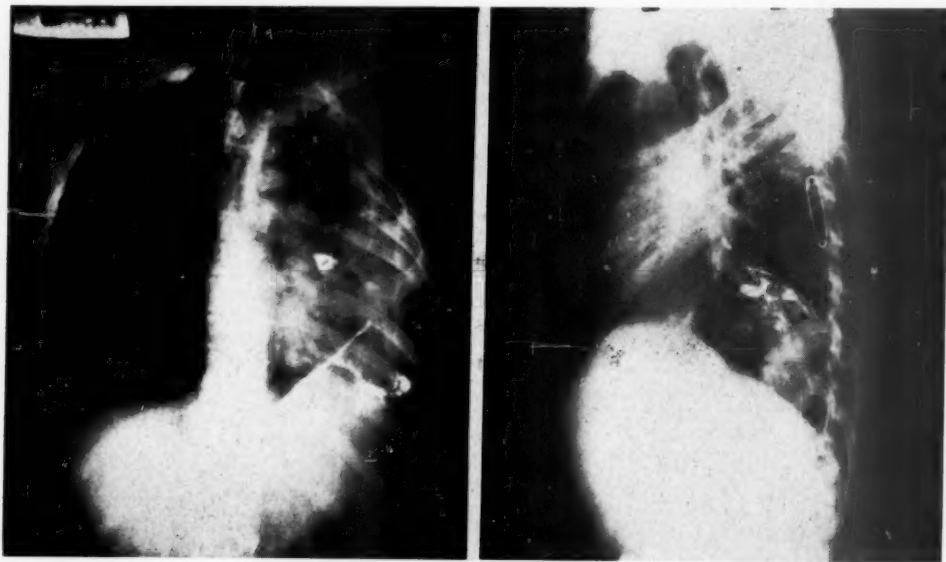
Posteroanterior and lateral roentgenograms of a fragment in the left auricle. Radio-opaque oil is seen in the empyema pocket.
